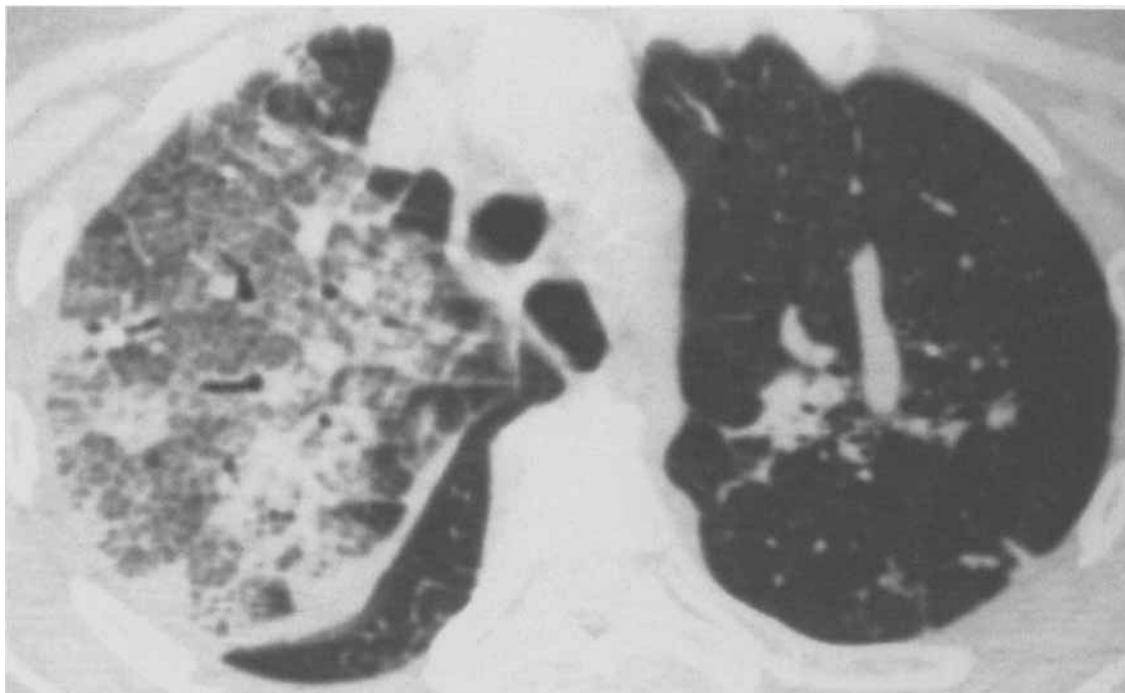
Candida albicans* pneumonia in a patient suffering from NHL. HRCT shows patchy air space consolidations localized in the upper lobe of the right lung and small nodules in the left lung without 'halo sign'.
